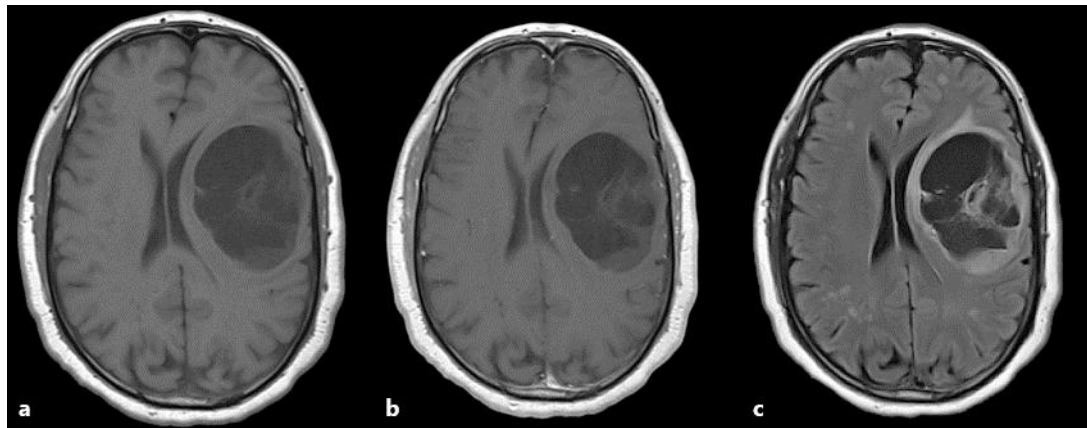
Brain MRI with and without gadolinium images at diagnosis. a T1 without contrast, b T1 with contrast, c FLAIR.
